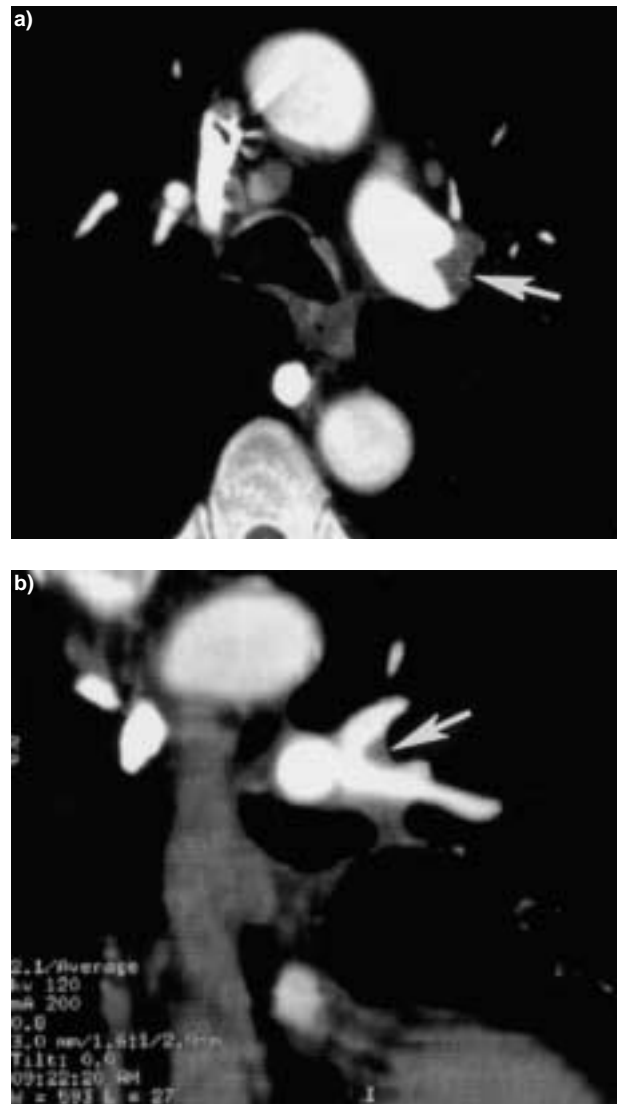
A 53-yr-old female with clinical suspicion of acute pulmonary embolism. Helical computed tomography angiography was performed with 3-mm sections. a) Axial computed tomography image at the level of the left pulmonary artery raises the suspicion of chronic pulmonary embolism (arrow). b) Coronal multiplanar reformation shows that low-density structure is due to externally located structure (arrow).
